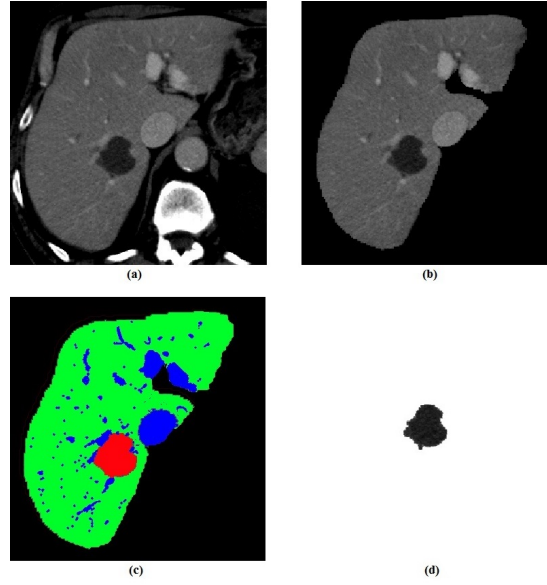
Steps of liver lesion segmentation process. (a) The original input CT image. (b) The segmented liver. (c) Operates AFCM to cluster the segmented liver into three areas where the green colour presents liver, lesion is red and vessels are blue. (d) The final result of the liver lesion segmentation.
